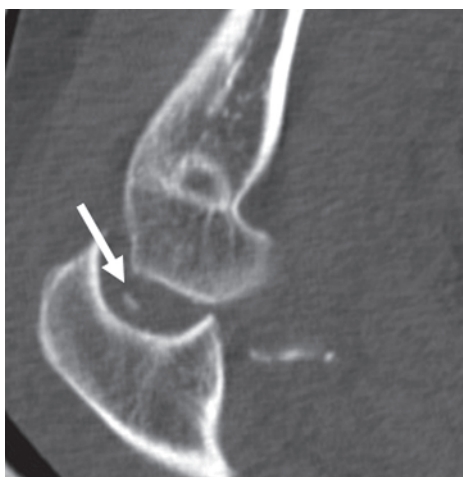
CT for detection of intra-articular bodies. Sagittal reformatted image through the olecranon shows an intra-articular ossific body (arrow) within the joint in a patient who sustained an elbow fracture-dislocation.
